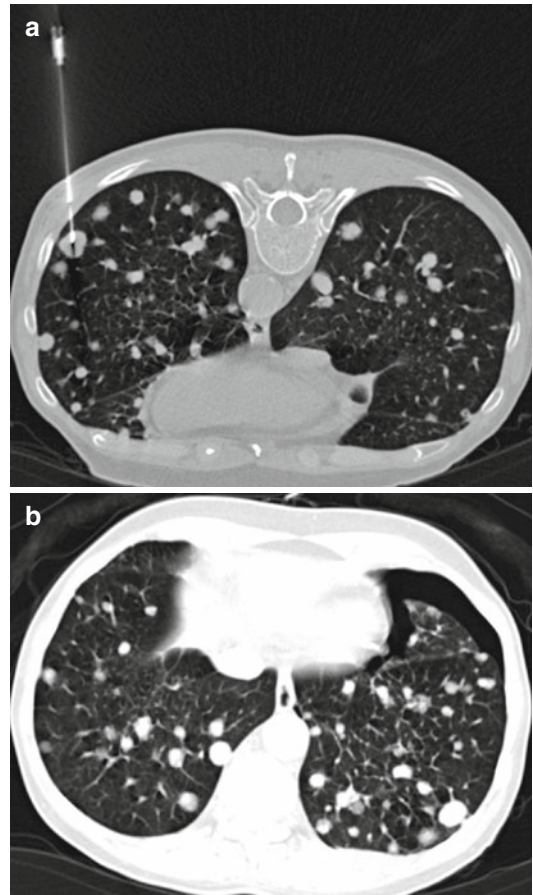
Patient (prone position) with multiple lung metastases. A subpleural nodule in the left lower lobe was chosen for aspiration biopsy under CT-fluoroscopic guidance with a 19-G (10-cm) needle (a). Postinterventional CT (supine position) showed a small pneumothorax that did not require therapy after further follow-up with X-ray (b). Cytology revealed pulmonary metastases of an adenocarcinoma (sigmoid colon)
